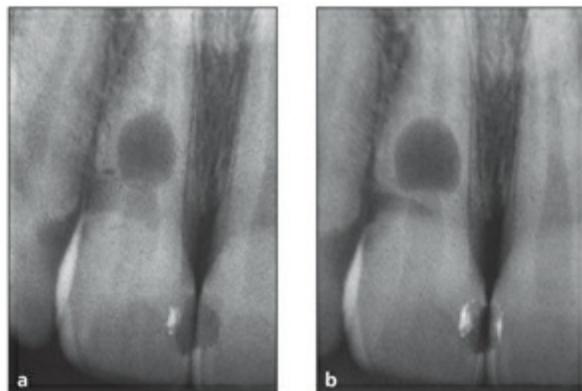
(*a and b*) Internal resorption. Radiographs from two different horizontal projections depict the lesion within the confines of the root canal.
